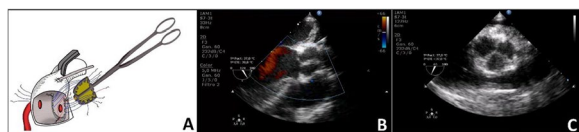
(abstract A165) 3D Model of Pericardial Harvest Device. B: Echocardiographic view demonstrating competence of AVaTAR Valve without regurgitation. C: Echocardiographic view demonstrating symmetrical coaptation of oversized AVaTAR valve.
